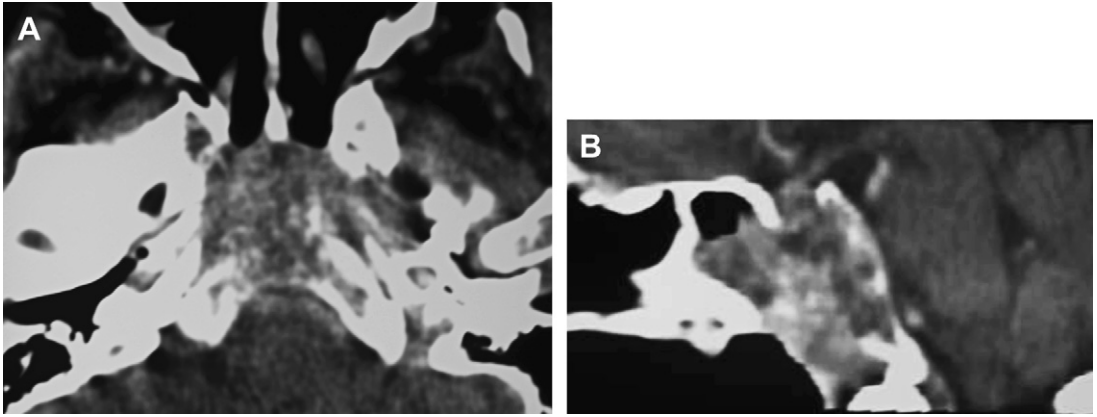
Contrast-enhanced axial (A) and sagittal (B) CT reconstruction on a soft tissue window show a destructive lytic lesion centered on the clivus and eroding its cortical margins, with an associated soft tissue mass enhancing heterogeneously in a man with a prior history of colonic adenocarcinoma (clival metastasis).
